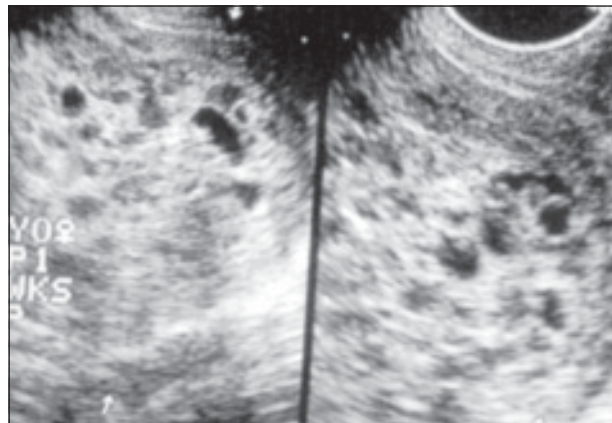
Ultrasonogram of a woman with hydatidiform mole at 19-week pregnancy (a “snow storm”)
